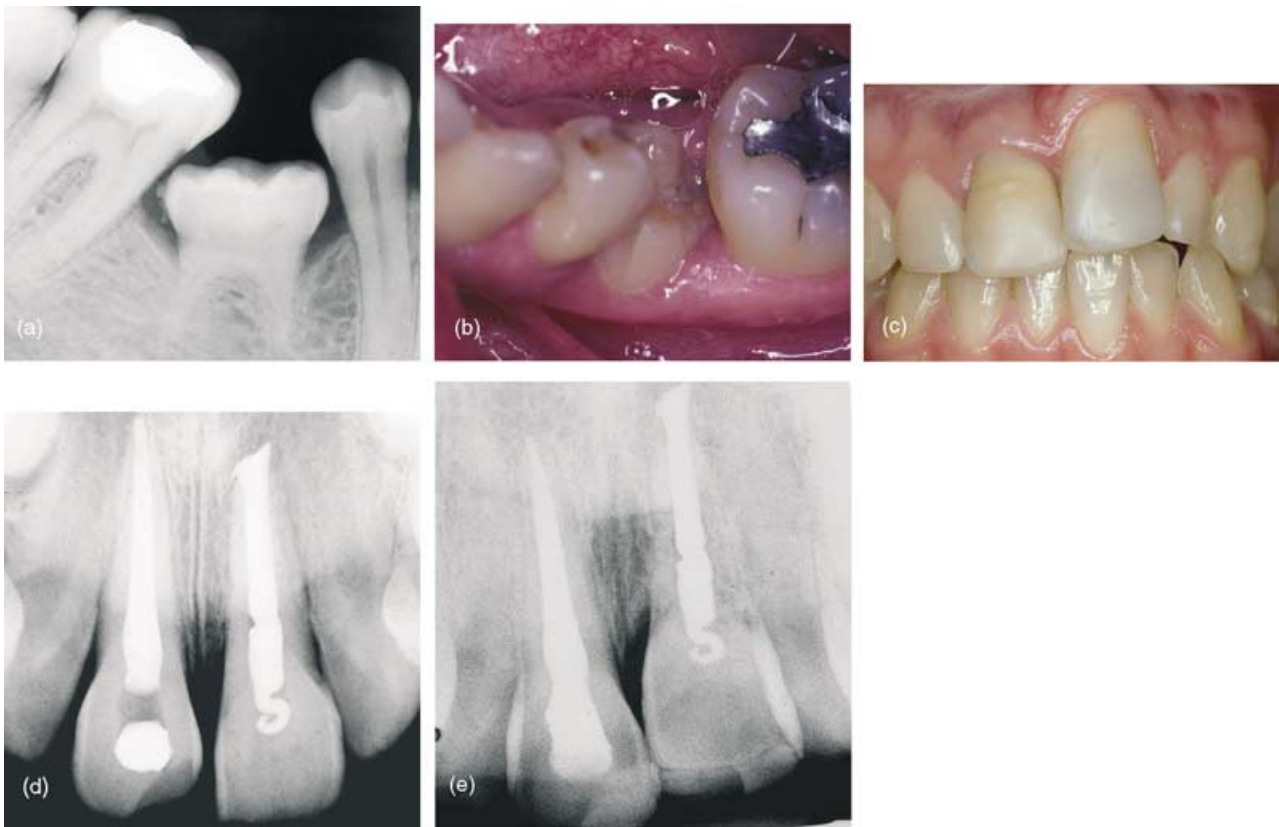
Radiologic (a) and clinical (b) picture of an ankylosed primary molar, which came into infraocclusion because of the normal eruption of the neighboring elements. The crown of the primary tooth has almost completely disappeared under the gingiva, and the neighboring teeth are angulated. The radiograph shows how the bone has grown with the definitive teeth, but around the primary tooth the processus has remained at a lower
